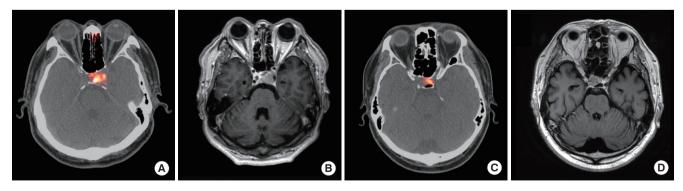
Images of 68 gallium-DOTATOC (68 Ga-DOTATOC) positron emission tomography/computed tomography (PET/CT) and magnetic resonance imaging (MRI). (A) ⁶⁸Ga-DOTATOC PET/CT image. It showed increased ⁶⁸Ga-DOTATOC uptake in the left sellar region. (B) MRI. A 2.9 cm-sized solid cystic lesion with left cavernous sinus invasion. (C) ⁶⁸Ga-DOTATOC PET/CT image. Focal ⁶⁸Ga-DOTATOC uptake was observed in left lateral wing of sellar area on 68Ga-DOTATOC PET/CT. (D) MRI. A 1.4 cm enhancing lesion with hemorrhage was located in the right lateral wing on MRI.
